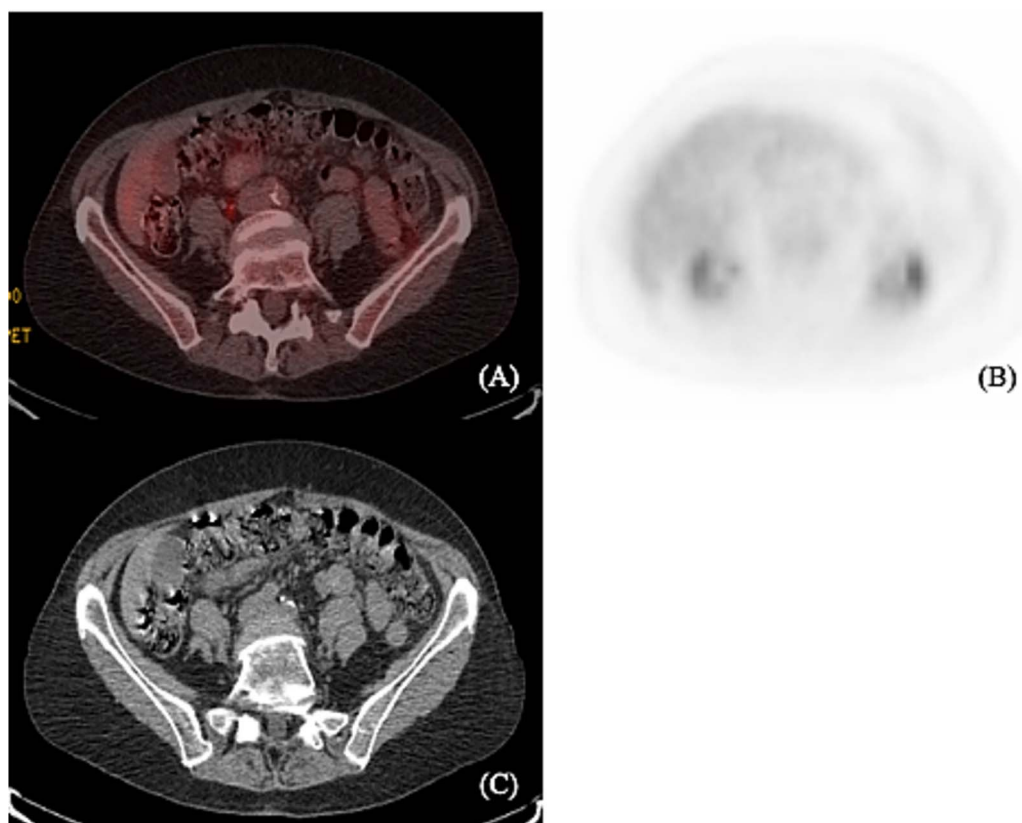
(A) and (B) show axial PET scan sections with 2.2 uptake in the liver. There is no abnormal colonic uptake. Specifically, there is no uptake seen in the splenic flexure corresponding to the mass described on the prior colonoscopy. (C) Computerized tomography shows no mediastinal lymphadenopathy and no axillary lymphadenopathy. Liver and spleen not enlarged. A prominent left inguinal lymph node was noted without evidence of abnormal FDG activity.
